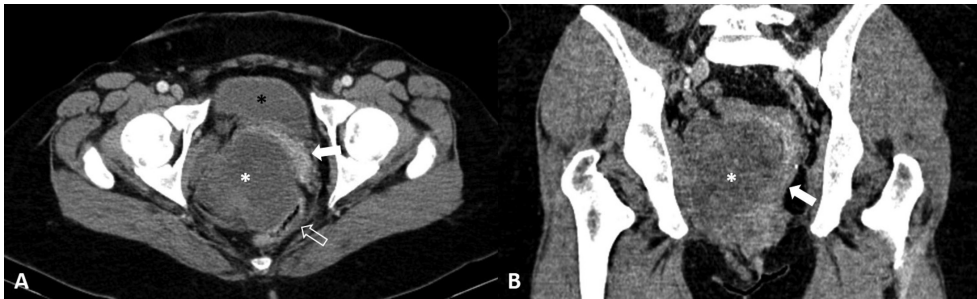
Axial contrast-enhanced CT (A) and coronal reformatted (B) images showing a heterogeneous lesion (white asterisk), extending from the right ischioanal fossa to the vaginal dome. The rectum is displaced laterally (white open arrow) and the vagina (white arrow) anteriorly and laterally, with no fat plane identifiable with this structure. Black asterisk, bladder.
